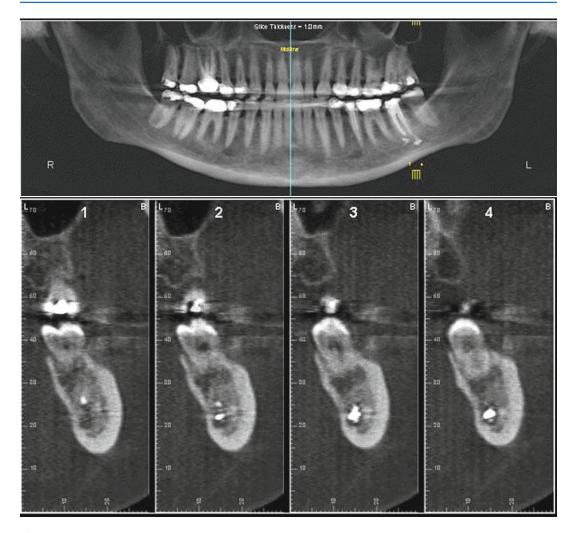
Panoramic and CT image demonstrating endodontic filling material expressed beyond the apex of the lower left first molar into the inferior alveolar canal
